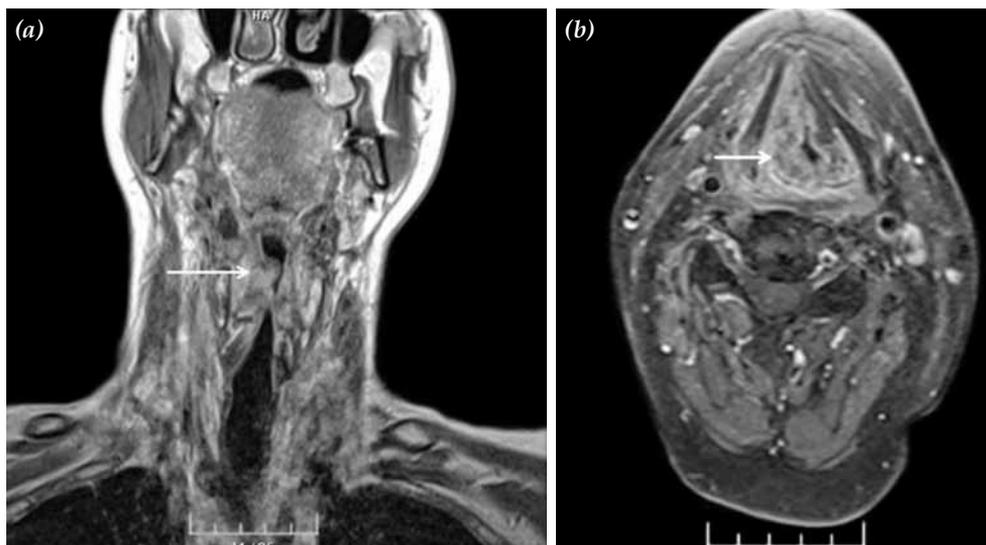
(a) Coronal, and (b) axial magnetic resonance imaging of the patient. A 3x1.5 cm contrast-enhancing solid mass is seen extending from hypopharynx to the right vocal cord (arrow). The mass is narrowing the airway.
